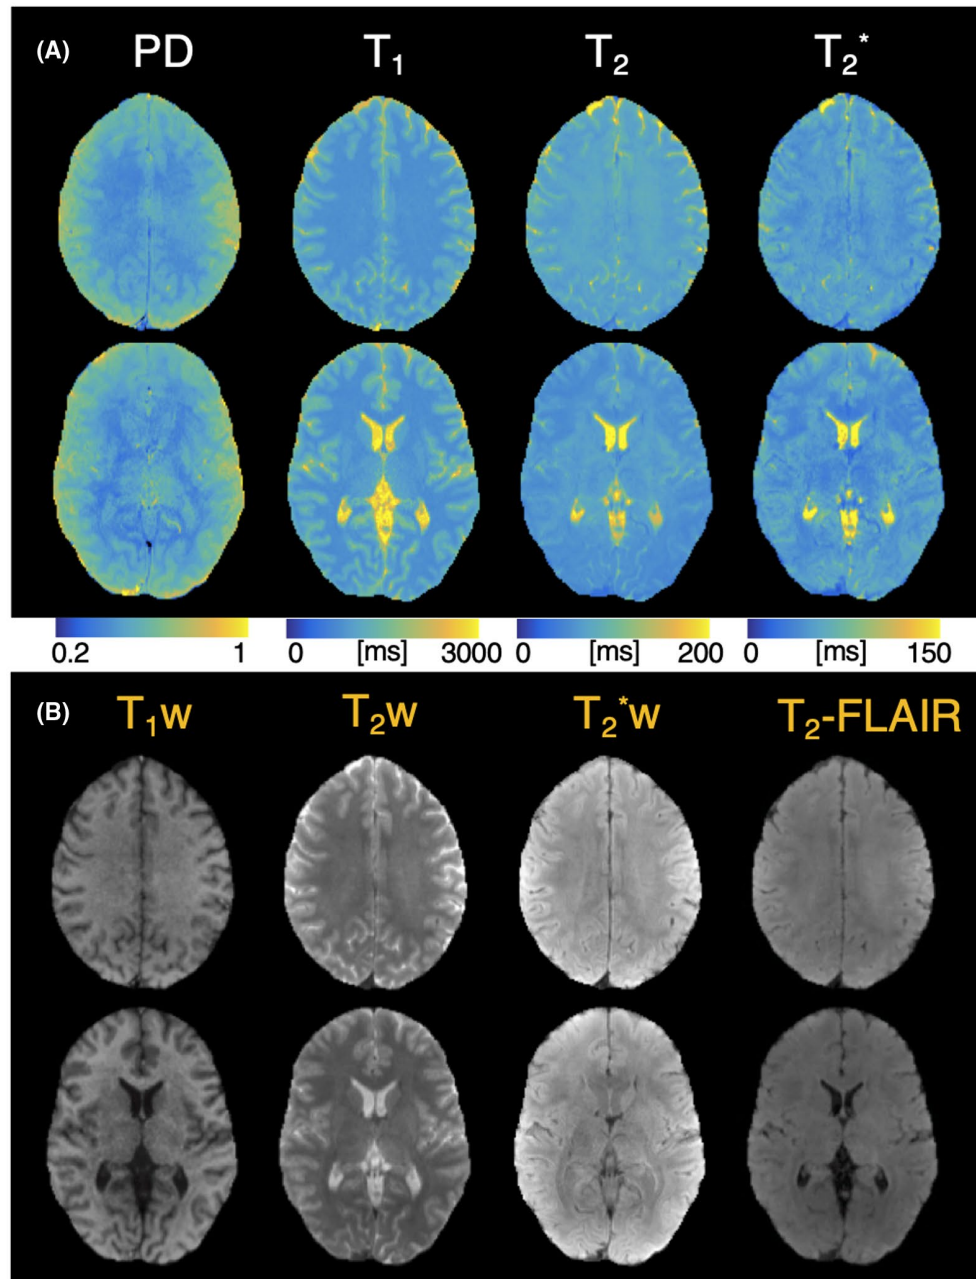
A, Quantitative parameter maps from two slices from protocol B, an MB acquisition (MB = 2, in-plane R = 4). B, Synthetic weighted contrasts from both slices show T₁w, T₂w, T₂*w, and T₂-FLAIR images
